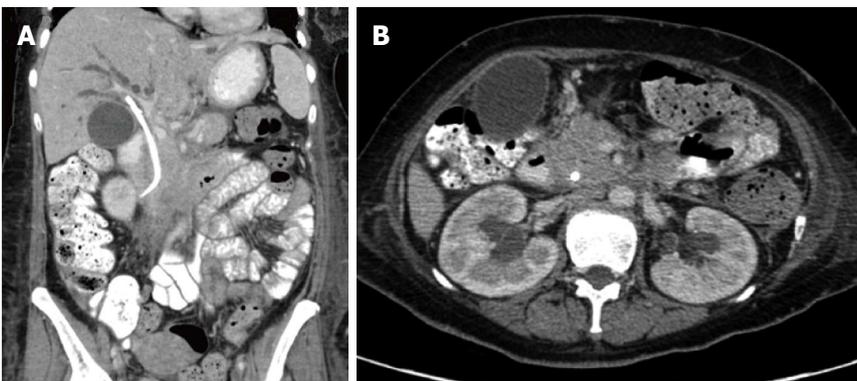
Computed tomography scan of the abdomen revealing an extensive retroperitoneal soft tissue mass. A: Sagittal view; B: Transverse view.
